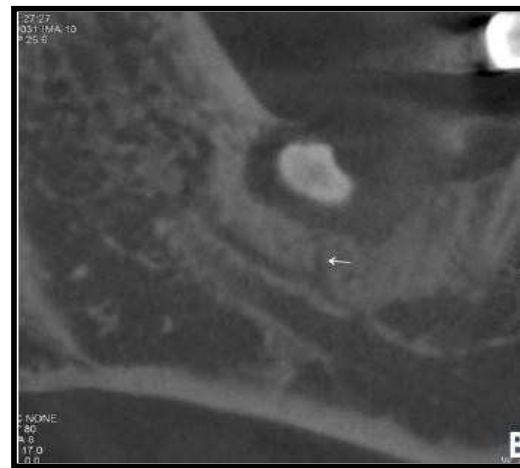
CBCT images show canal type 5B (trifid canal type: two accessory canals of one dental type)
